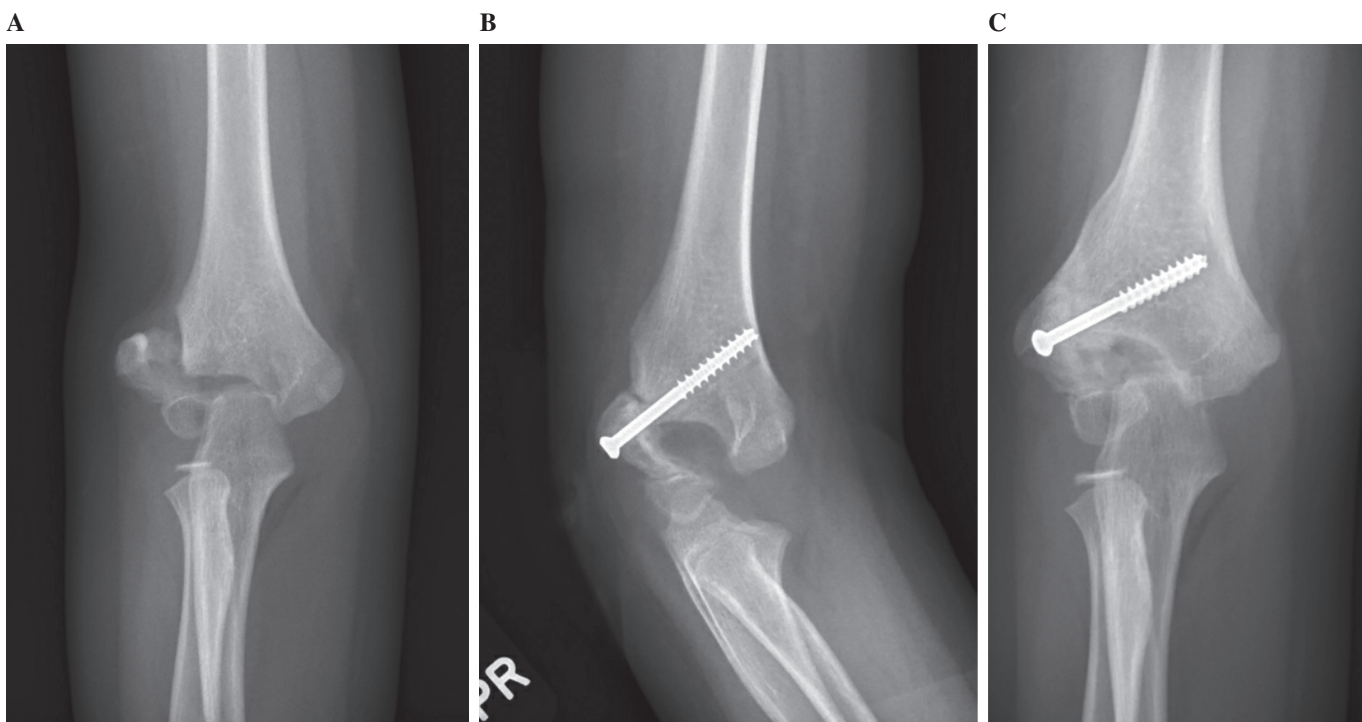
AP radiographs of the right elbow (A) in an 8-year-old patient with an established lateral condyle nonunion, who presented with elbow discomfort and limited motion 4 months after sustaining a fall after climbing a tree at their home. The patient underwent local bone grafting with in-situ fixation with a cannulated screw and K-wire augmentation. At the 3-month postoperative visit, AP radiograph demonstrated a persistent nonunion (B). He subsequently underwent a formal nonunion repair with bone grafting and revision screw fixation, achieving osseous union (C).
